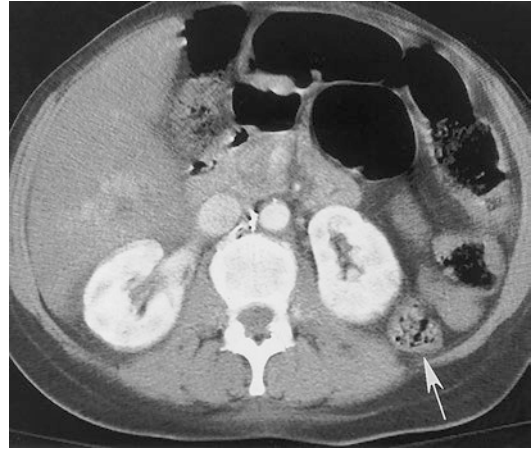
CT image showing a retrorenal colon, prone to get injured during percutaneous renal access
